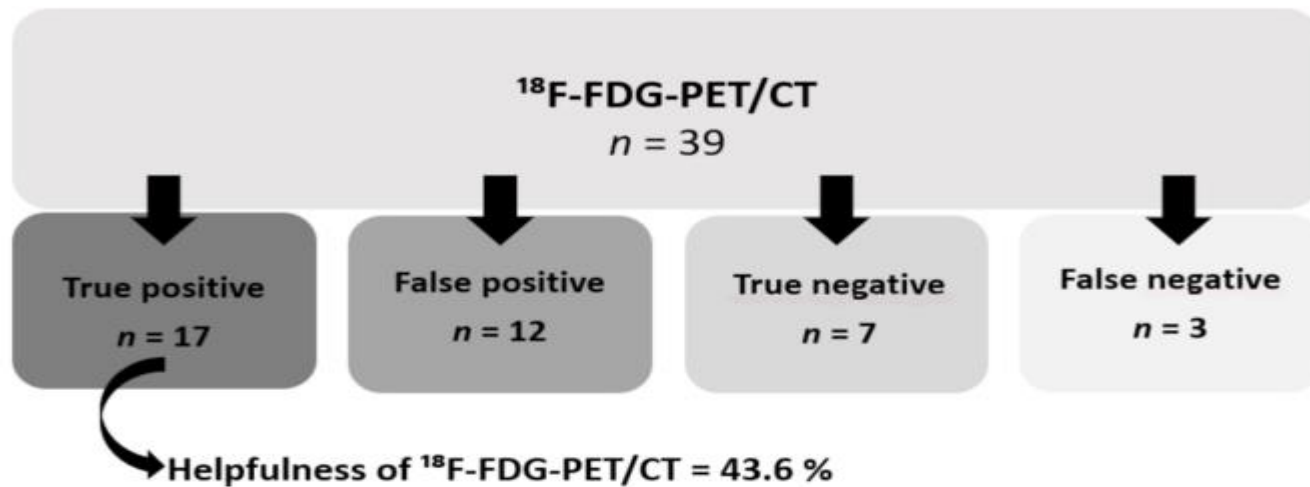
Diagnostic contribution of ^{18}F -FDG-PET/CT.
